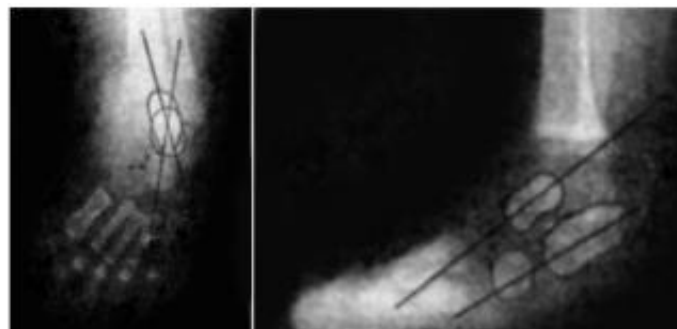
Radiographical View of Talocalcaneal Angle both Normal and CTEV.
